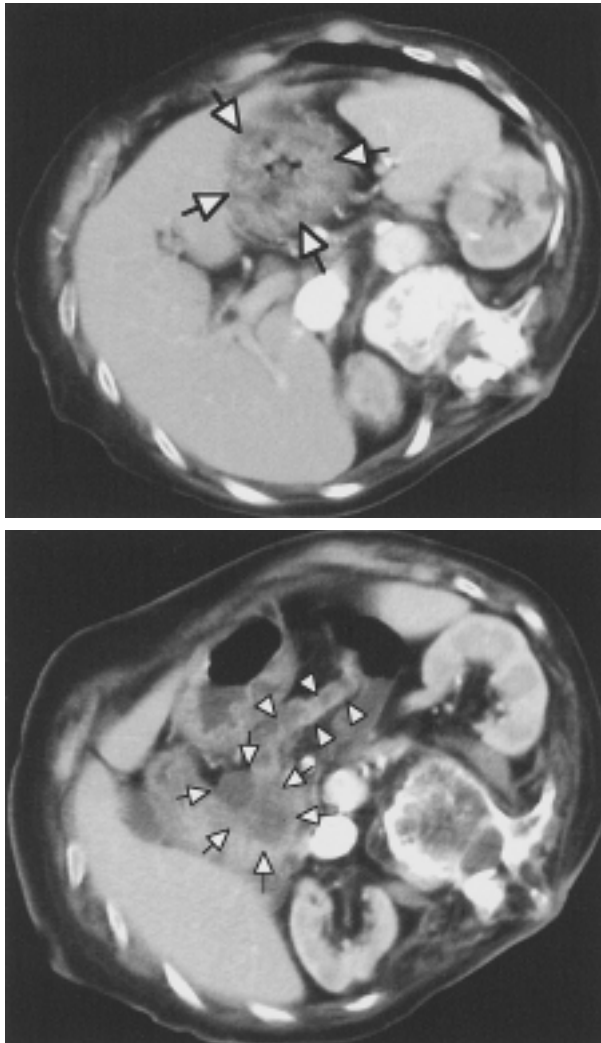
Abdominal CT scan revealed thickened gastric mucosa (arrows) which is densely enhanced by a contrast enhancement (upper panel). A tumor was found in the head of the pancreas (arrows) and the pancreatic duct (arrow heads) was dilated (lower panel).
